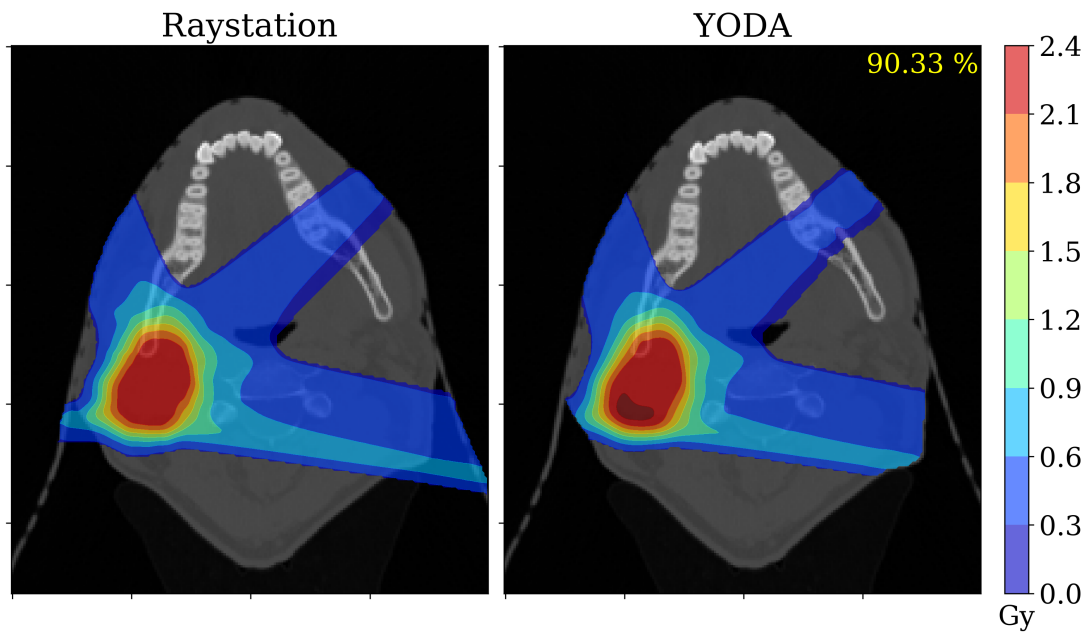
Dosimetric comparison between RayStation and YODA for the Patient 3. The figure displays RayStation (on the left) and YODA (on the right) two-dimensional dose cuts, overlaid on the corresponding CT slice. The figure displays in the top right corner of the YODA plot, the three-dimensional gamma index passing rate using 2 mm, 2% and 10% cut-off.
